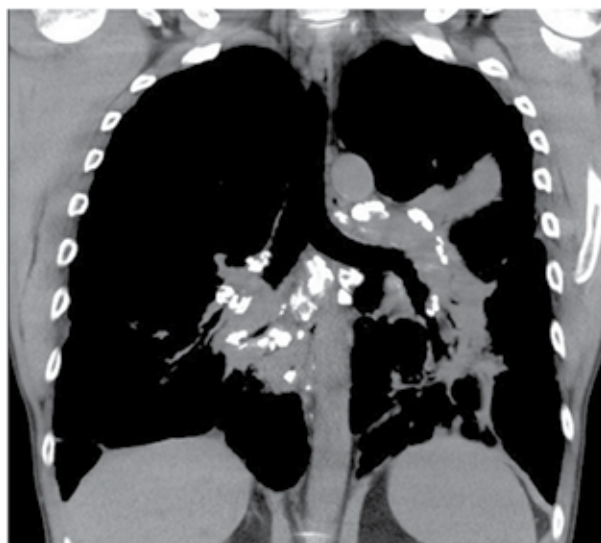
Coronal reconstruction of a chest CT scan with a mediastinum window setting showing calcifications affecting lymph nodes in several mediastinal and hilar chains. Also note evidence of fibrotic distortion in the perihilar regions.
